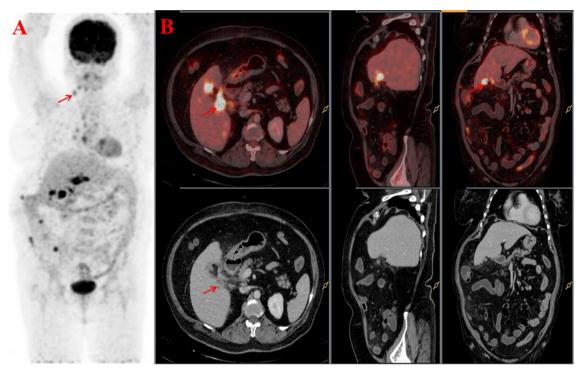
18F FDG PET/CT scan of a 61-year-old women was having right hypochondriac pain and pT2 stage and negative on PET/CT A, Maximum intensity projection image (MIP) B, PET/CT and corresponding CT at the gallbladder fossa region
